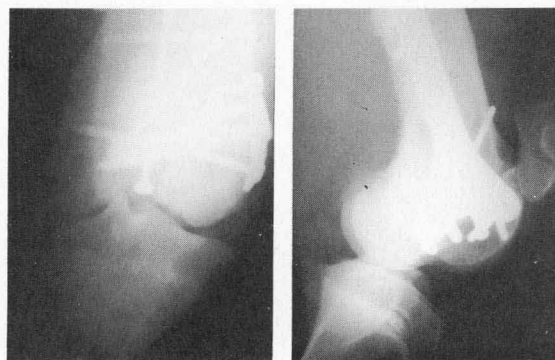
Caudal [left] and lateromedial [right] radiographic views 20 weeks after surgery. Primary bone healing has been achieved.
